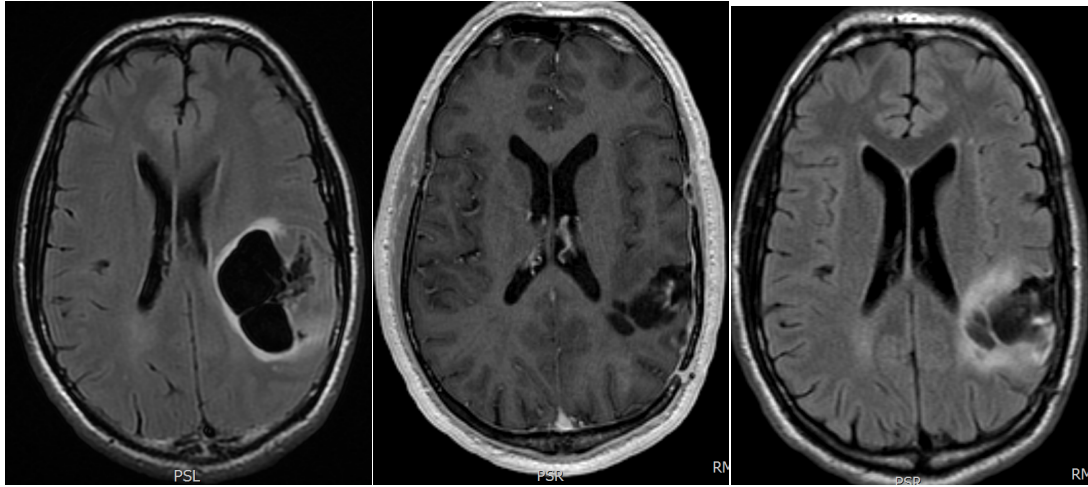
Brain MRI post gadolinium: axial cut. The frontotemporal meningioma recurrence is depicted
